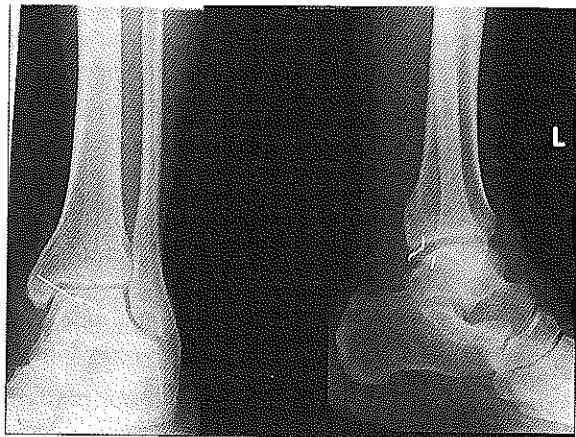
Antero-posterior and lateral radiograph of left ankle showing a metallic object within the ankle joint.
